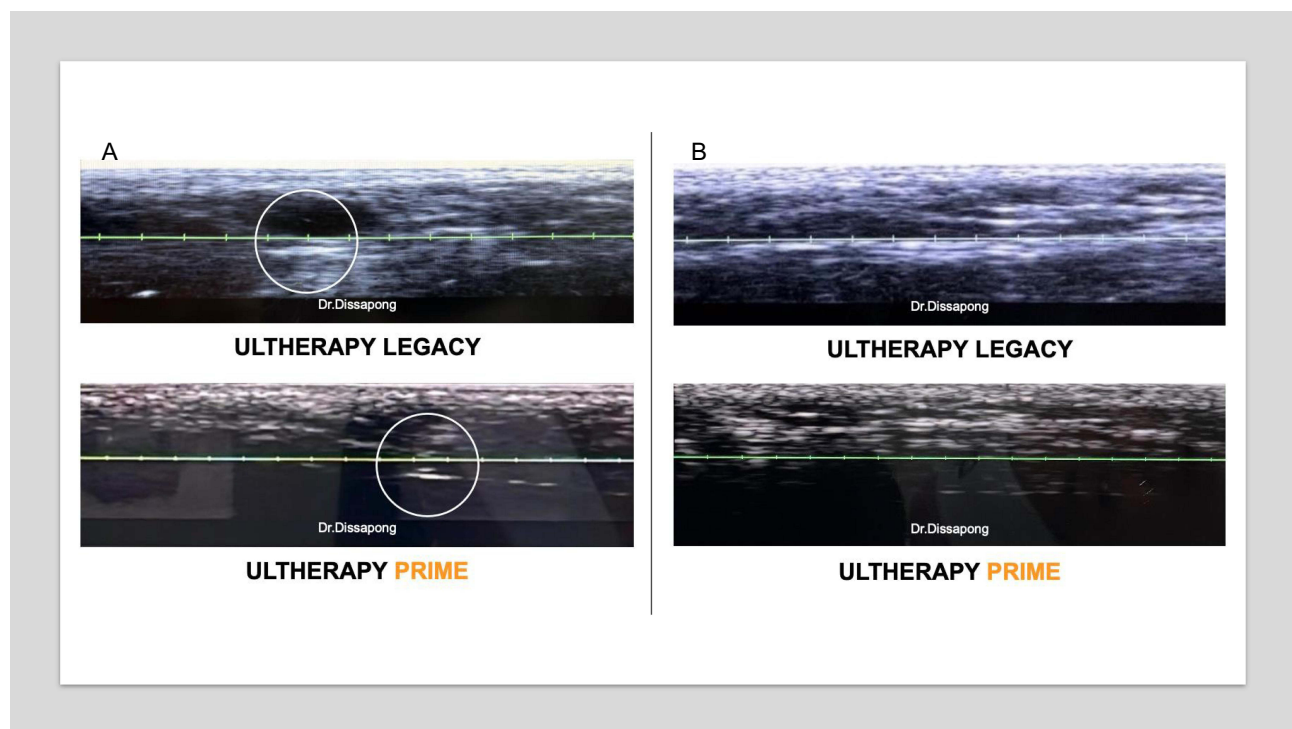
Ultrasound visualization using the 4.5 mm transducer on the right side of the face at the same anatomical site. (A) Comparison between Ultherapy Legacy and Ultherapy Prime focusing on the visualization of titanium implants. (B) Comparison between Ultherapy Legacy and Ultherapy Prime focusing on the superficial musculoaponeurotic system (SMAS). The circles highlight the implants.
